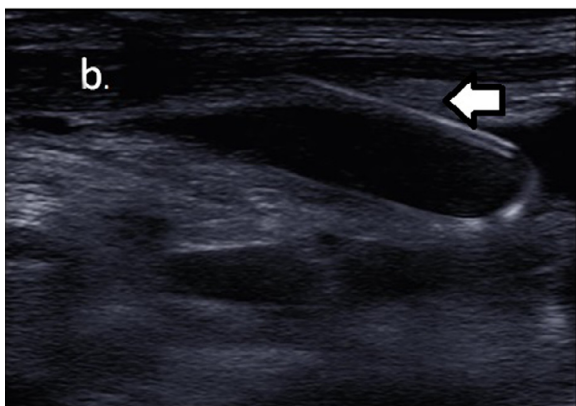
Ultrasonography of the right internal jugular vein. White arrow indicate that the foreign body is both inside and outside the blood vessel.
